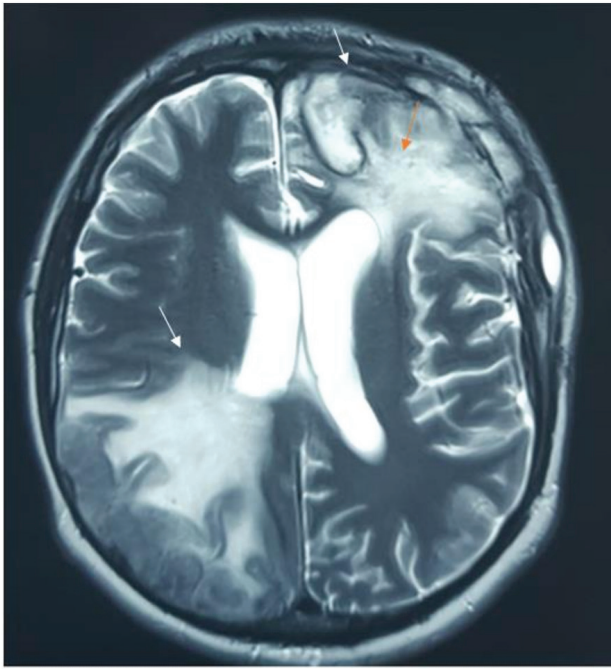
Axial T2-weighted magnetic resonance imaging showing an extra-axial mass-like process in the left frontal and right parietal regions, appearing isointense on T2 sequences (white arrows). There is associated perilesional edema in the adjacent white matter, appearing hyperintense on T2 (orange arrow), which is causing a slight mass effect on the ventricular structures.
